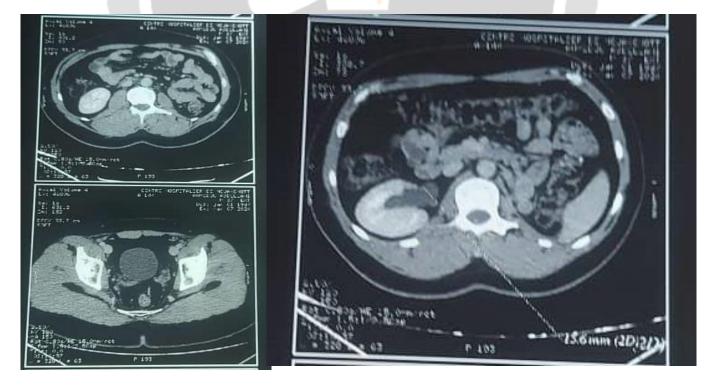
The postoperative follow-up urological CT scan after 3 months
